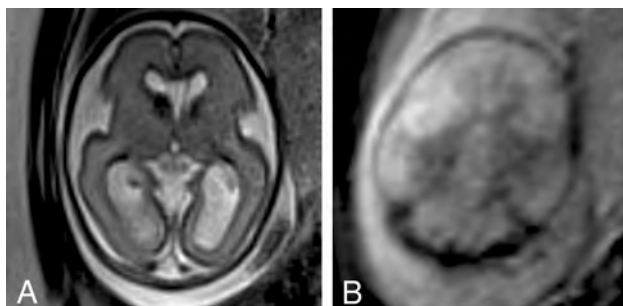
Twenty-five weeks' gestation. A 1.5T, single-shot T2-weighted EPI (A) shows the right foramen of Monro dominant nodule/enlarged GE and the normal GE on the left. T2*-weighted image (B) demonstrates no blood products in the mass.
